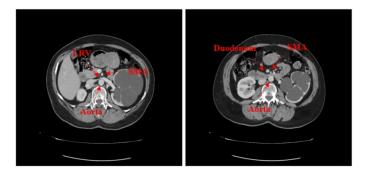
Computed tomography of the upper abdomen, in the arterial phase of the contrast medium, in axial section: In the leftsided image, a notable stenosis of the left renal vein (LRV) is evident between the aorta and the superior mesenteric artery (SMA). Simultaneously, the left kidney appears dilated with hydronephrosis and significant parenchymal thinning. The rightsided image reveals compression of the third portion of the duodenum between the aorta and the superior mesenteric artery (SMA), along with associated changes in the left kidney.
